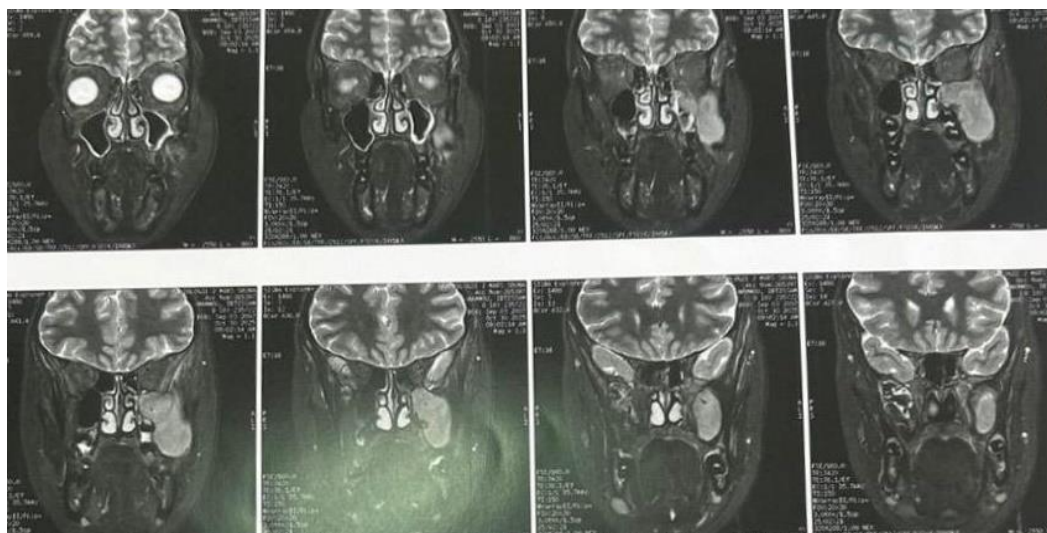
Gadolinium-enhanced T1-weighted MRI showing intense tumor enhancement with multidirectional extension along neural pathways toward the pterygopalatine ganglion.
